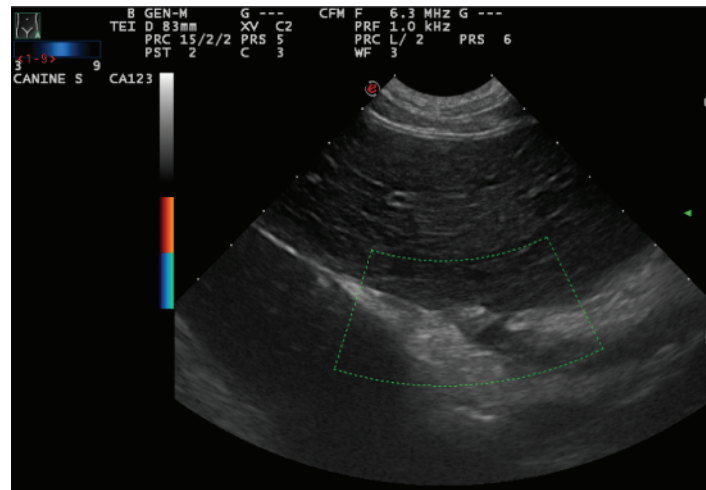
Splenic torsion. Ultrasound image from a 6-year-old Great Dane with a splenic torsion. Note the “lacey” appearance to the spleen with Doppler evidence (green dashed lines) of decreased flow (courtesy Dr. Robert O’Brien, DVM, DACVS).
